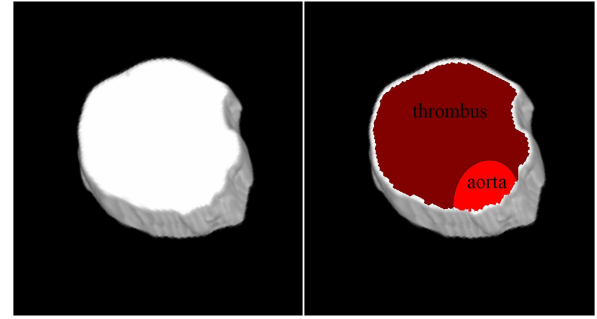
Result (consecutive 2D sections) of 3D segmentation for an abdominal aorta thrombus without aorta (first) and with aorta (second) computed in CTA data using the edge detection function with anisotropic diffusion.
